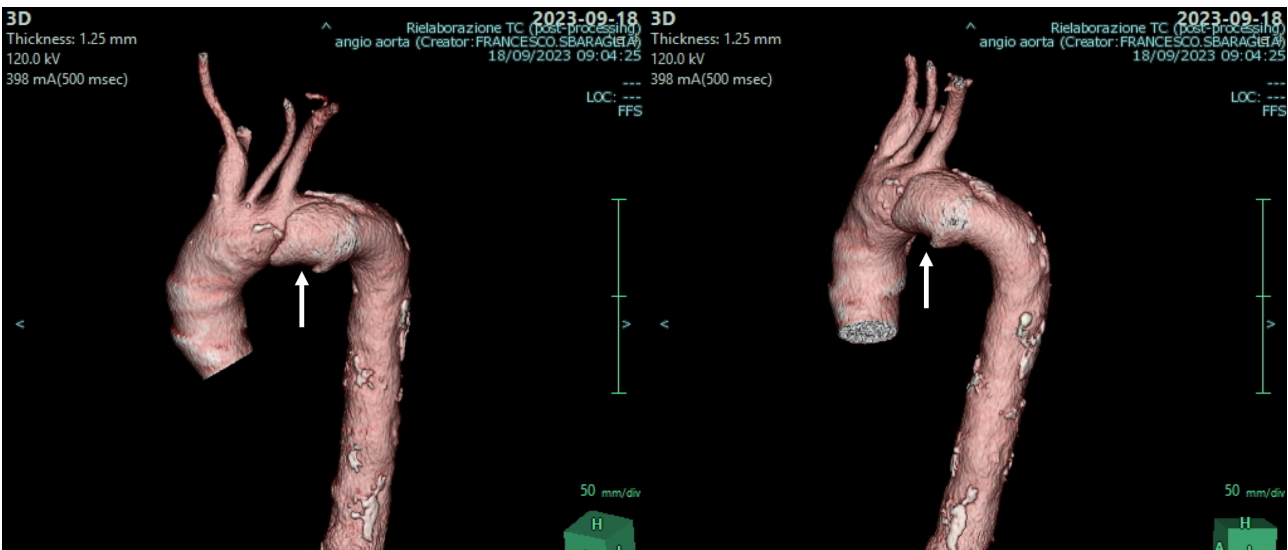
3D volume-rendering processing of the thoracic aorta angio-CT showing the “localized” dissection of the aortic arch (arrows).
